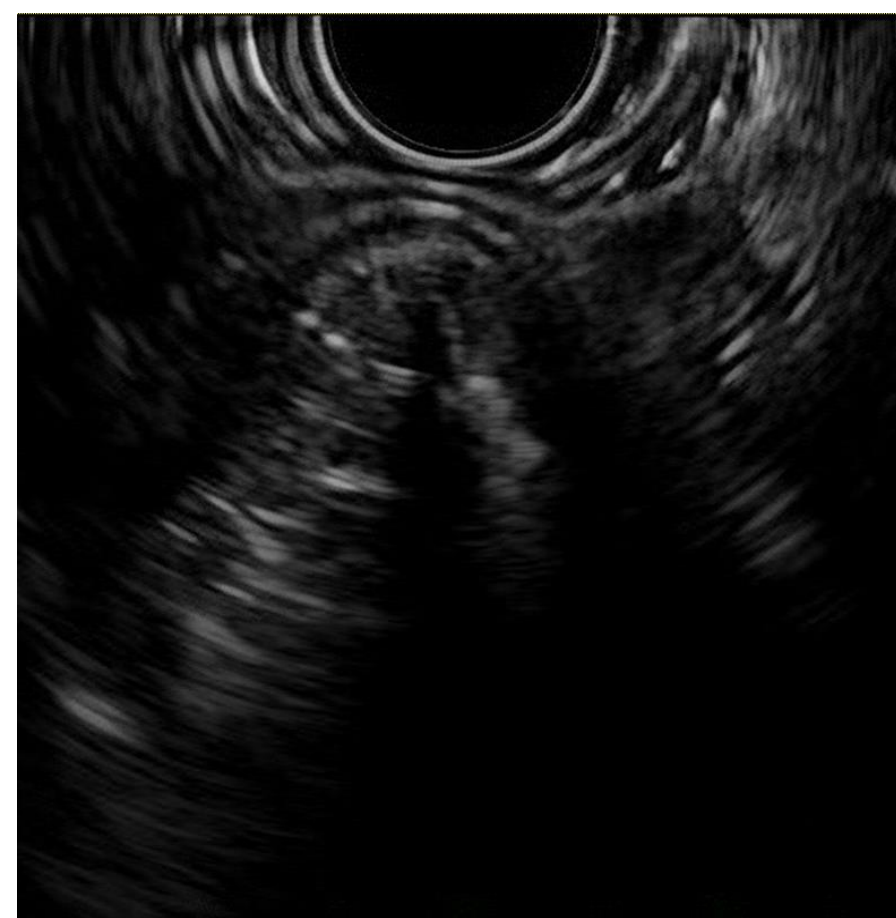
Endoscopic ultrasound of gastric lesion demonstrating a hyperechoic, multilayered, shadowing lesion external to the stomach
